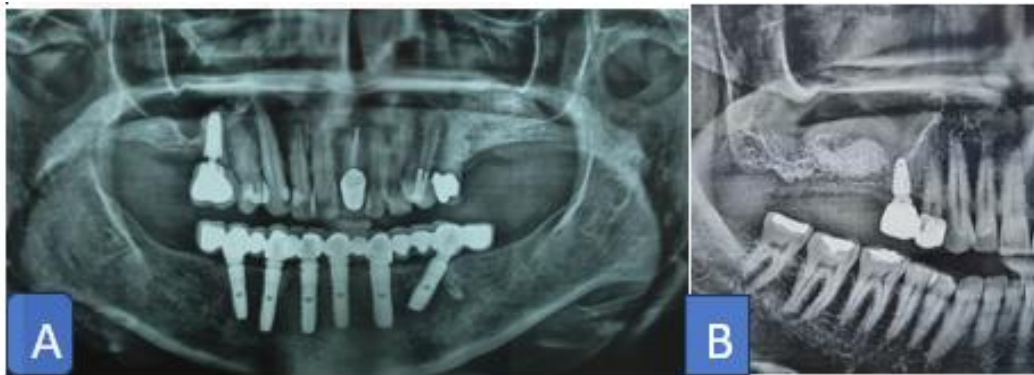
A & B, Postoperative radiograph (orthopantomogram) evaluates the sinus lift procedure and bone formation before implant placement
